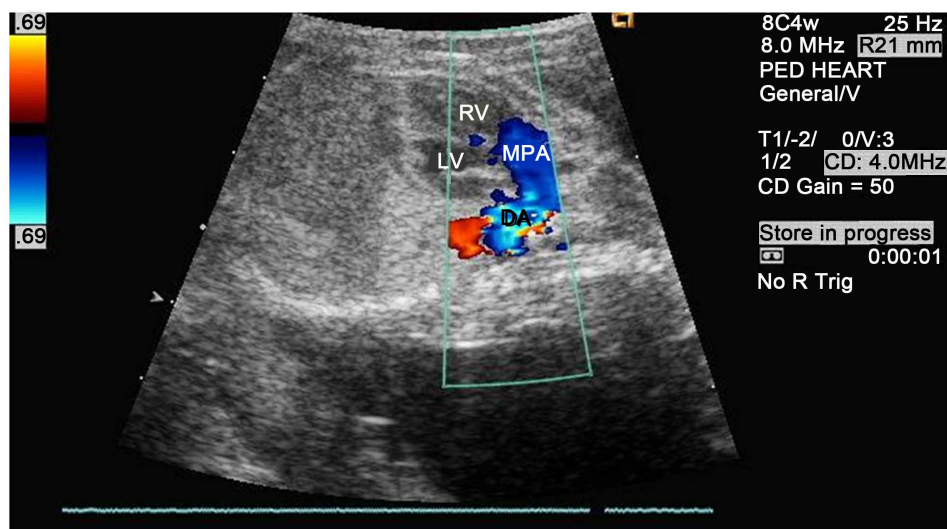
2D/Color Doppler fetal echocardiographic image showing turbulence in the ductus arteriosus consistent with premature ductal construction. RV: right ventricle, LV: left ventricle, MPA: main pulmonary artery, DA: ductus arteriosus.
